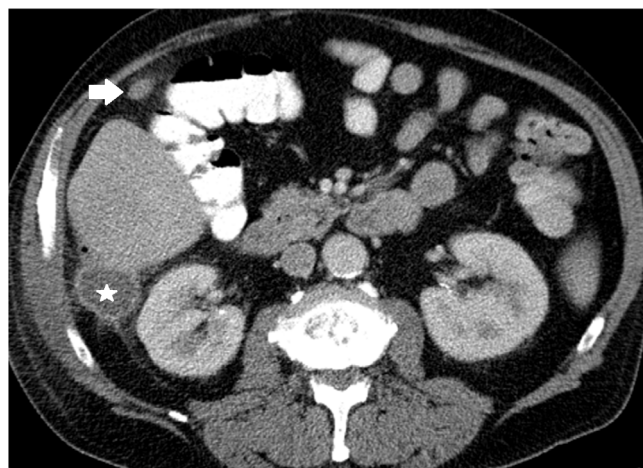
Transverse CT scan of the abdomen visualizes the location of the IPT (arrow) and abscess formation between the liver and the kidney (asterisk) (courtesy of Prof. Dr. A. Mahnken, Department of Diagnostic and Interventional Radiology at Marburg University Hospital)
